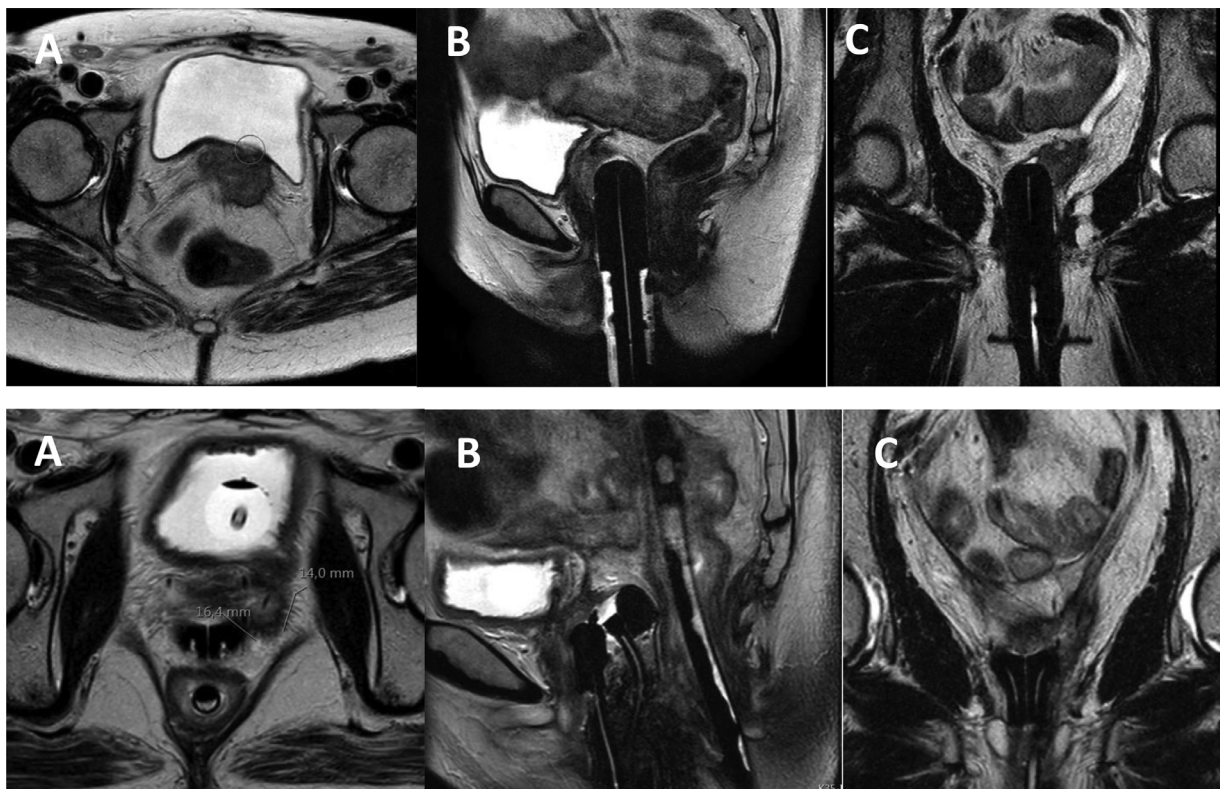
MRI images at time of initial recurrence in Panel 1 (A – axial, B-sagittal, C-coronal) and at the time of brachytherapy in Panel 2 (A- axial, B-sagittal, C-coronal). Residual tumor measurements noted on bottom panel A. Additional details of the case are described in the methods section of the manuscript. Of note, a rectal tube can be seen most clearly on the sagittal image in Panel 2.
